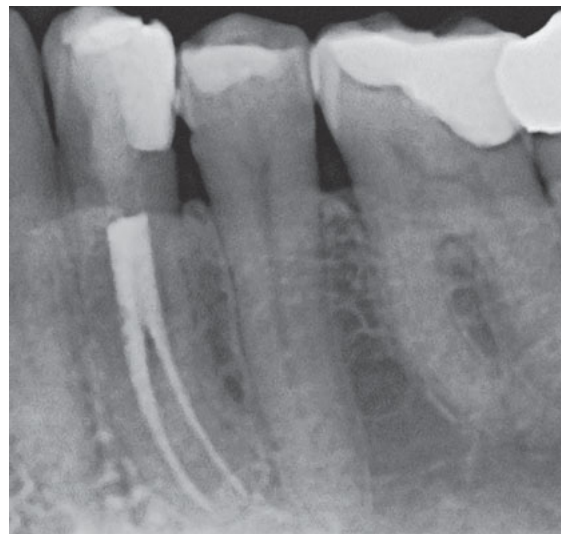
6-month follow up indicating healthy apical bone structure with no radiographic sign of periapical pathology.
